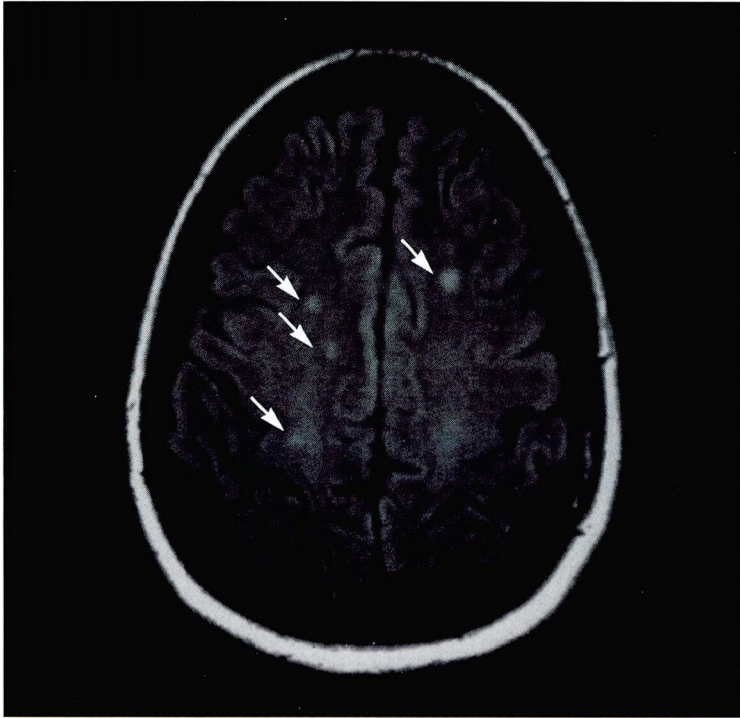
T2-weighted, fluid-attenuated inversion recovery (FLAIR) axial cranial magnetic resonance image showing four ovoid areas of increased signal involving the centrum semiovale dorsal to the lateral ventricles (arrows). The estimated lesion load is less than 1.23 cm³.
